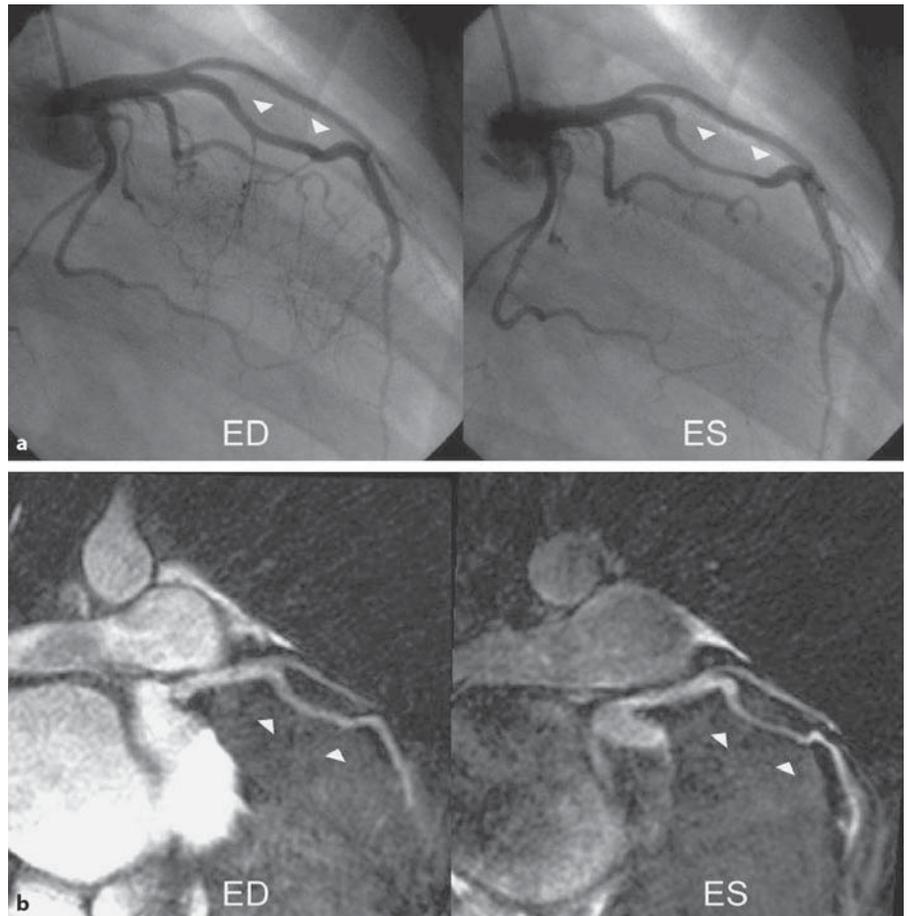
a Coronary X-ray angiogram in right anterior oblique view of the LAD artery showing the course of the middle segment of the artery entrapped within the myocardium (arrows) at the end-diastolic and the end-systolic phase during the cardiac cycle. Note the narrowing of the artery at end-systolic phase. b Corresponding right anterior oblique view of the LAD artery on the coronary MR angiogram allowing to identify the muscular bridge, the course of the middle segment (arrows) and the variation in diameter of the vessel between end-diastolic and end-systolic phases.
